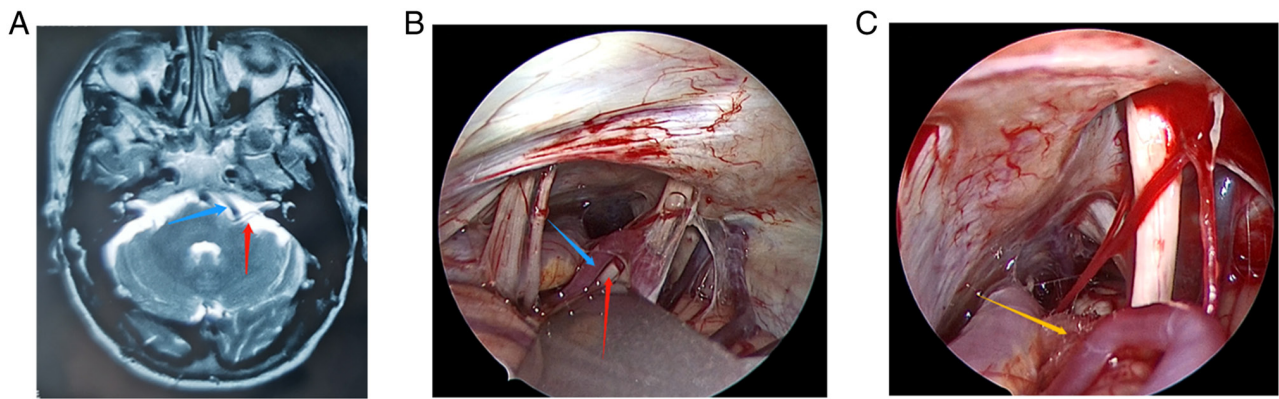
Patient 1. (A) Preoperative head magnetic resonance imaging of the patient. (B) The anterior inferior cerebellar artery and compressed cranial nerves were clearly visible under the endoscopic view. (C) The Teflon pad was placed between the root exit zone of cranial nerve 7 and the anterior inferior cerebellar artery under the endoscopic view. Red arrows indicate the compressed cranial nerve vessels, blue arrows indicate the anterior inferior cerebellar artery and the yellow arrow indicates the Teflon pad.
